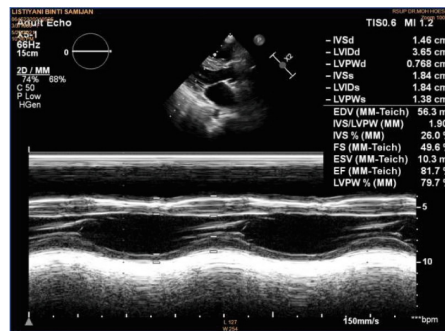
Echocardiography showed ejection fraction after ASD closure
